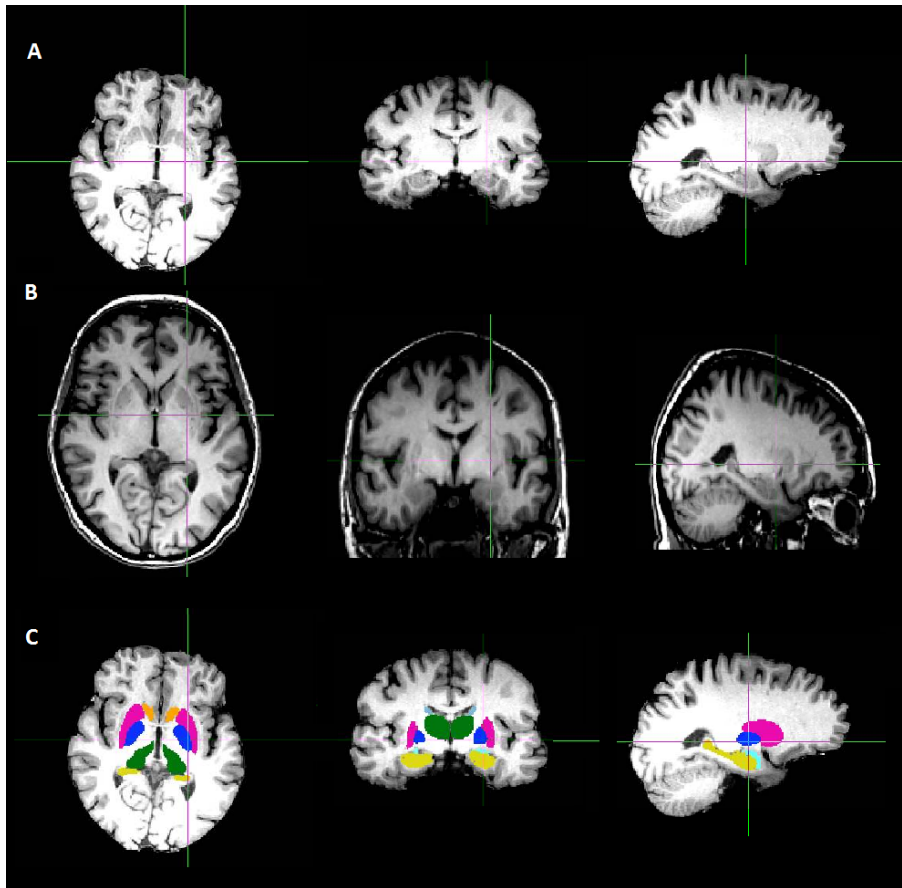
A - MRI image with a contrast enhancement for better distinction of basal ganglia structures; B - T1-MRI image after two-stage affine registration to the MNI space; C - Fusion of the MRI enhancement images with the caudate nucleus (light blue), thalamus (green), putamen (pink), pallidum (blue), hippocampus (yellow), nucleus accubens (orange) and amygdala (fluorescent light blue) masks estimated with FIRST from Patient 1.
